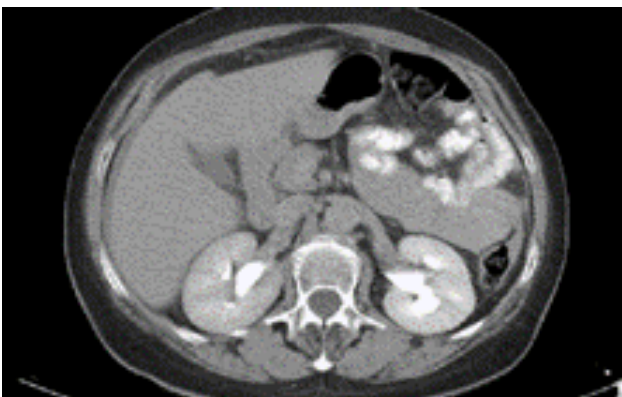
Axial CT of malignant peripheral nerve sheath tumor (hydronephrosis type 2 in the left kidney)
